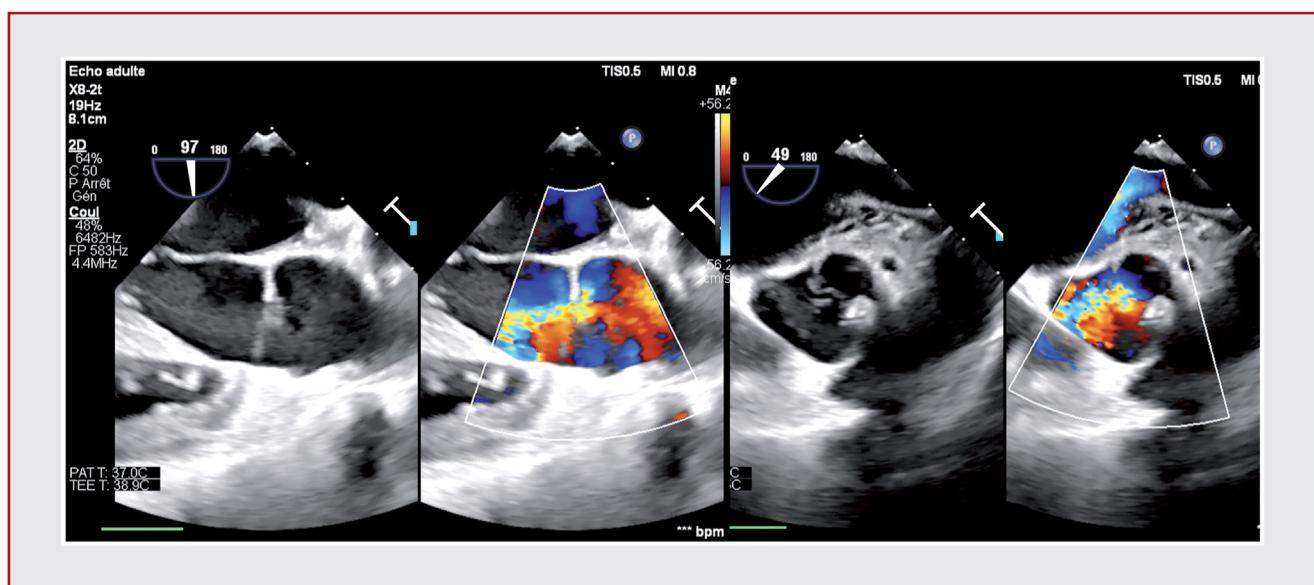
Significant aortic regurgitation following primary plasty. Left section: midoesophageal aortic valve long-axis view with or without colour-flow Doppler. Right section: midoesophageal aortic valve short axis view with or without colour-flow Doppler.
